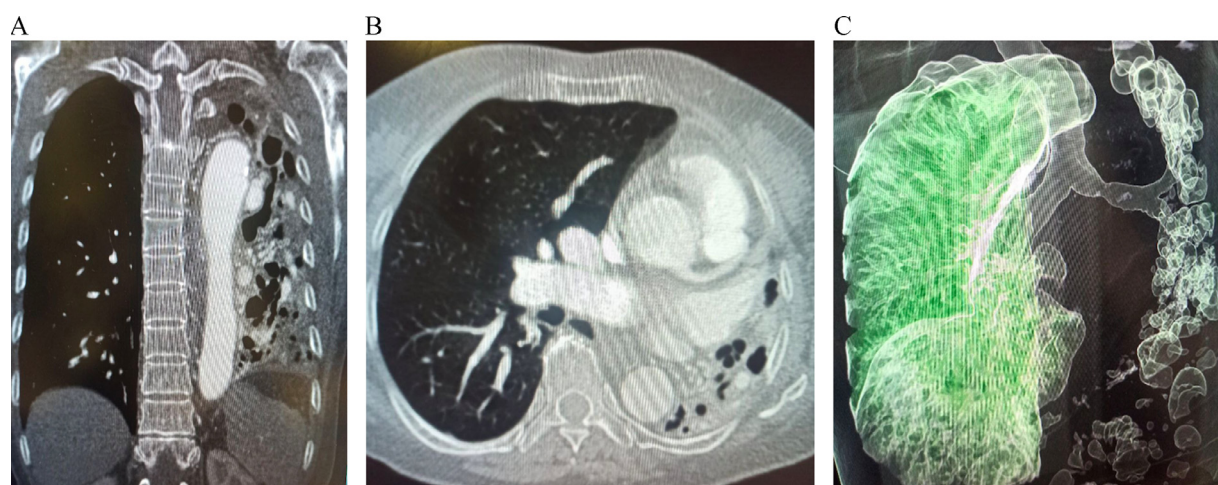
A. Coronal Contrast-enhanced CT chest showing cicatrization collapse of left lung with tubular and varicoid bronchiectatic changes in the periphery. B. Axial Contrast-enhanced CT chest showing the cicatrization collapse of the left lung with ipsilateral mediastinal shift and bronchiectatic changes in the periphery. C. 3D Volume rendered reconstruction image of the lung showing a collapsed left lung with multiple cystic lesions in the surroundings.
